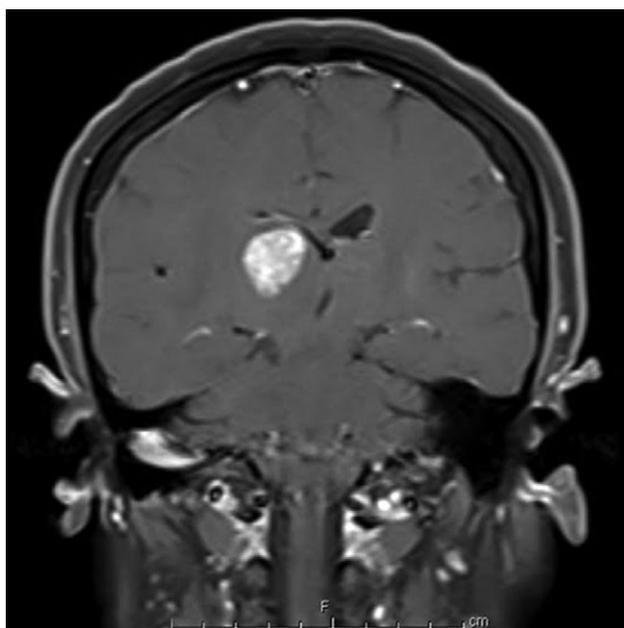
T1-weighted coronal MRI with gadolinium showed a mass lesion with heterogeneous contrast enhancement and mild peritumoral edema in right thalamus.
